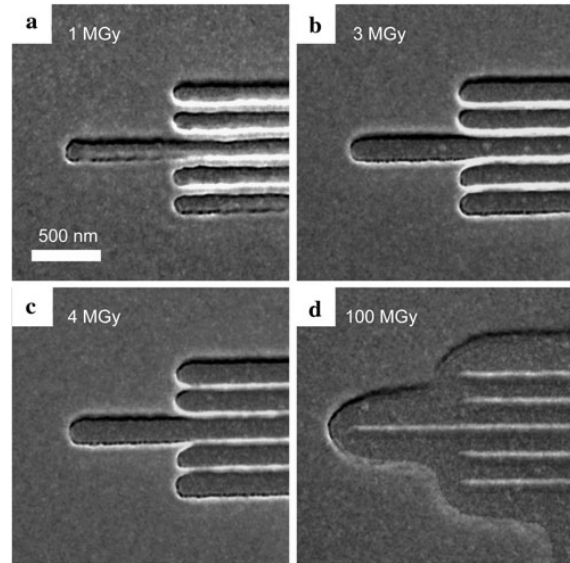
SEM images of identical elbow patterns directly written in PMMA with focused 300 eV monochromatic X-rays after development (all images are the same scale). (a) An optimum dose of 1 MGy produces the narrowest positive mode features. The developed linewidth increases with increasing dose (b), 3 MGy, (c) 4 MGy. (d) An extensive positive mode region extends beyond the high dose (100 MGy) negative mode regions. The crosslinked 1:1 lines of (d) are 90 ± 5 nm wide
